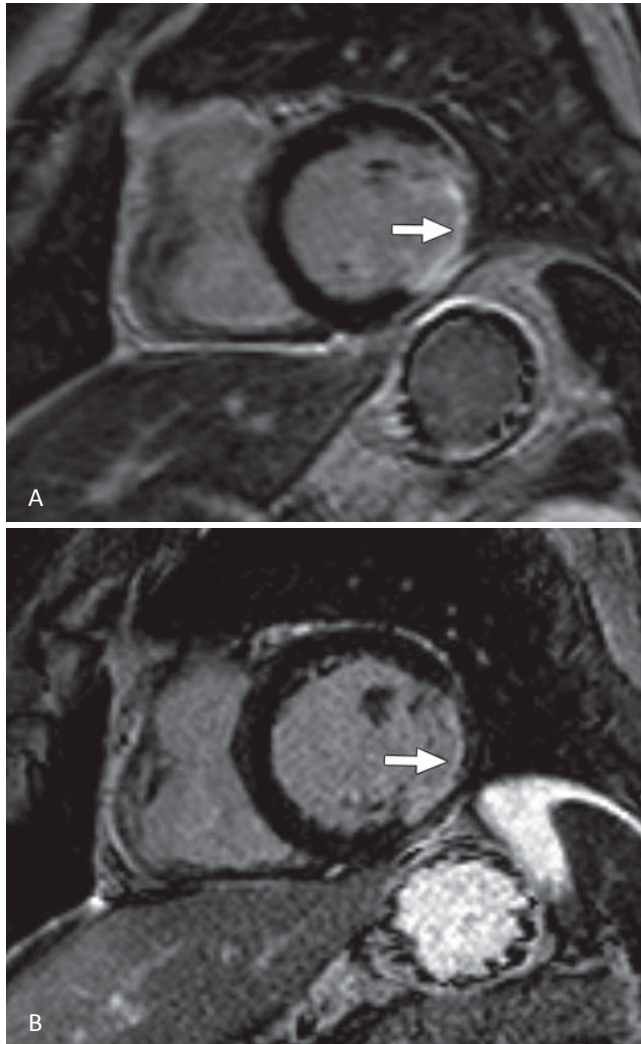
58-year-old man with myocardial infarction in inferolateral segment after occlusion of left circumflex artery. (A) Breath-hold 3D gradient-echo inversion-recovery delayed-enhancement MR image shows myocardial infarction (*arrow*) with hyperintense signal intensity. Extent of infarction is subendocardial. (B) Free-breathing 2D single-shot inversion-recovery SSFP delayed-enhancement MR image shows myocardial infarction (*arrow*) with hyperintense signal intensity. Extent of infarction is subendocardial. For both sequences area of infarction is identical.
